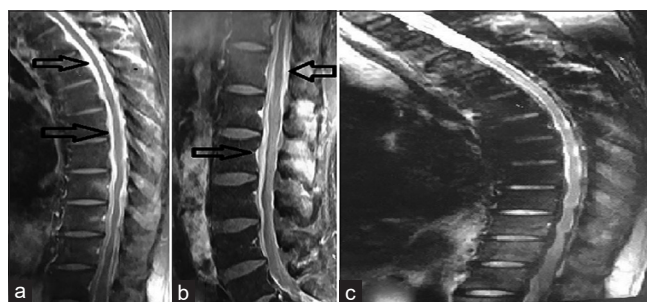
Sagittal Gd-enhanced T1-weighted magnetic resonance images of spine (a, b) shows diffusely thickening and enhancement of dura mater at T4 level and below (arrow); (c) T2-weighted magnetic resonance images of thoracic spine (c shows swelling of the spinal cord at the level of T4-T12)
